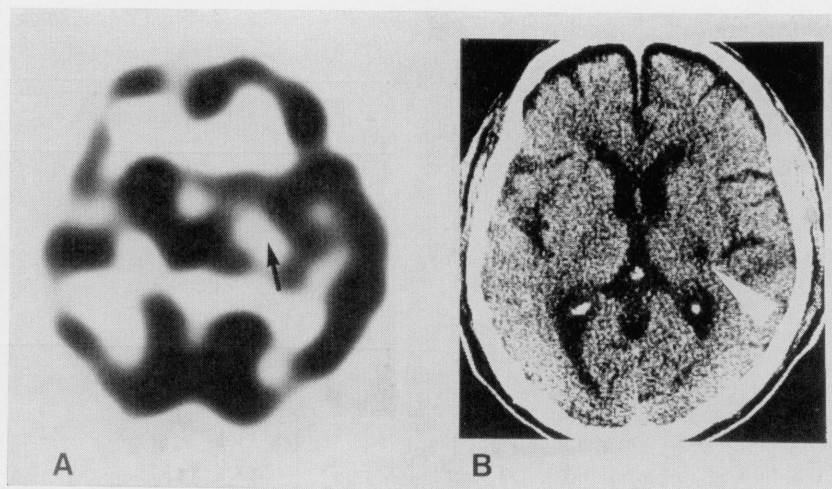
A: SPECT in a 78-year-old male 37 days after a transient symptom of right hemiparesis showing a hypoperfused area in the left lenticular-capsular region (indicated by black arrow). (B): Computed tomogram (CT) at the same level showing a small hypodense lesion in the posterior genu of the left internal capsule (indicated by white arrow head).
